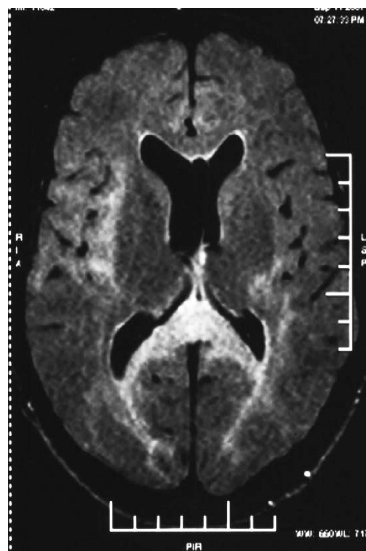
Magnetic resonance tomography of the brain, T2W/FLAIR axial image
